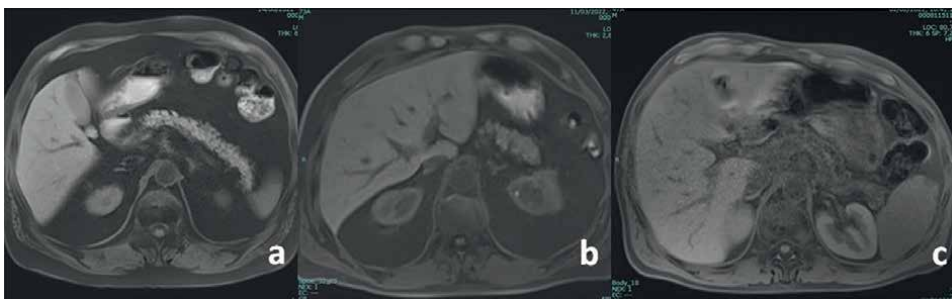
T1w GRE fat-sat MRI scan comparing a normal pancreas (a), a mild CP (b) and an advanced CP (c), where the non-enhanced T1 intensity of the gland is gradually reduced according to the severity of CP.
